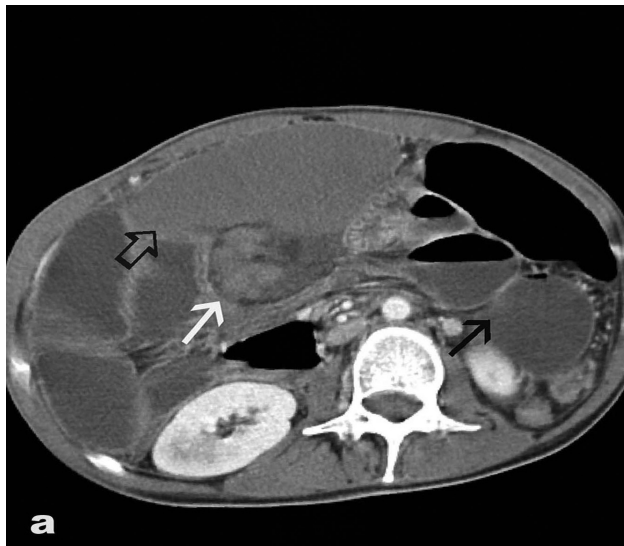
a: Contrast-enhanced axial CT view of the totally infarcted spleen located in the right mid-abdomen (open arrow). The twisted splenic pedicle involved thrombus in the splenic vessels and hamartoma (white arrow). The patient had splenic torsion accompanied by small bowel dilatation (black arrow). 1b: The operative findings of the patient with wandering spleen compressing the intestines (black arrow) and two loops of dilated small bowel (white arrow). 1c, d: Microphotographs showing different parts of the vascular lesion located in the spleen hilus. The lesion was composed of back-to-back, dilated, vascular structures (HE x40).
